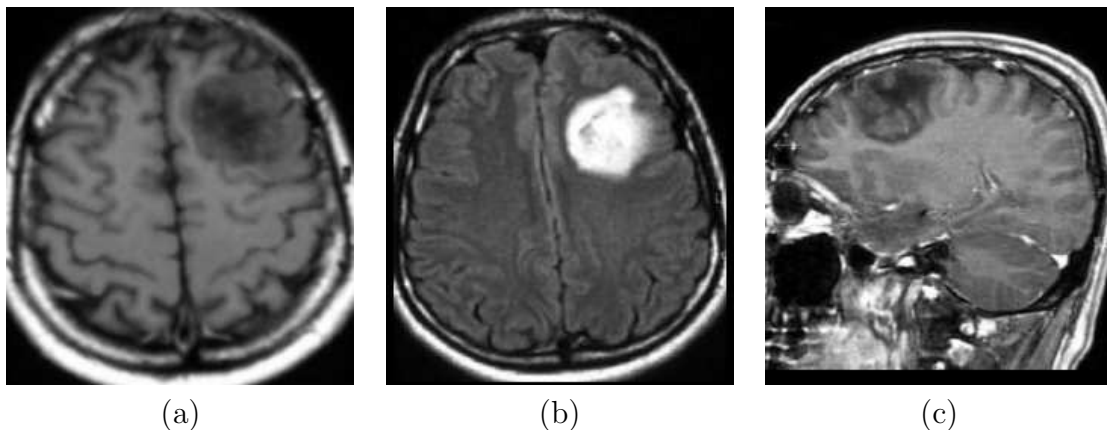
Low grade oligodendroglioma. a) Non enhanced tumor in axial slice of contrast enhanced T1-weighted image. b) Same tumor on FLAIR. c) Sagittal view of the tumor [Emedicine, 2005].
